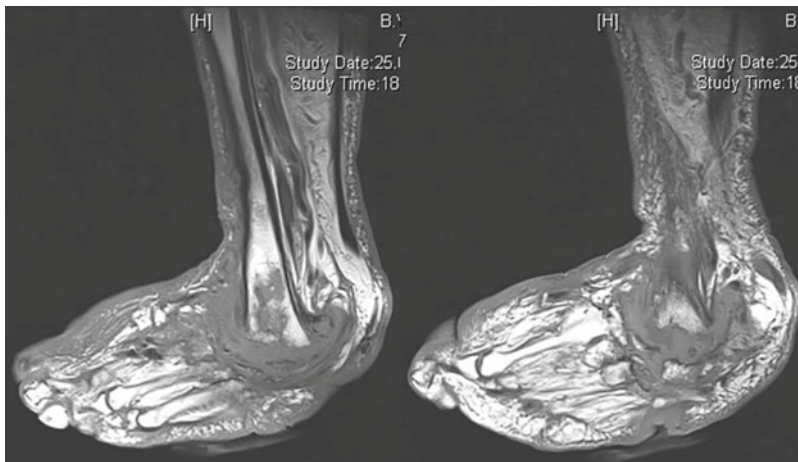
Magnetic resonance imaging of a 63-year-old male patient presented with Charcot arthropathy (Case 17.4)
